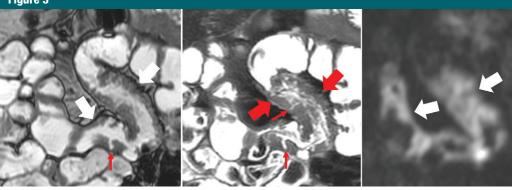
Imaging findings of jejunal stricture with severe inflammation at MRE with marked asymmetric wall thickening (*left, white arrows*), bowel wall edema on T2-weighted imaging with fat saturation (*middle, large red arrows*), small ulcers (*left and middle images, small red arrows*), and increased intramural signal on high b-value diffusion-weighted image (*right, white arrows*).
